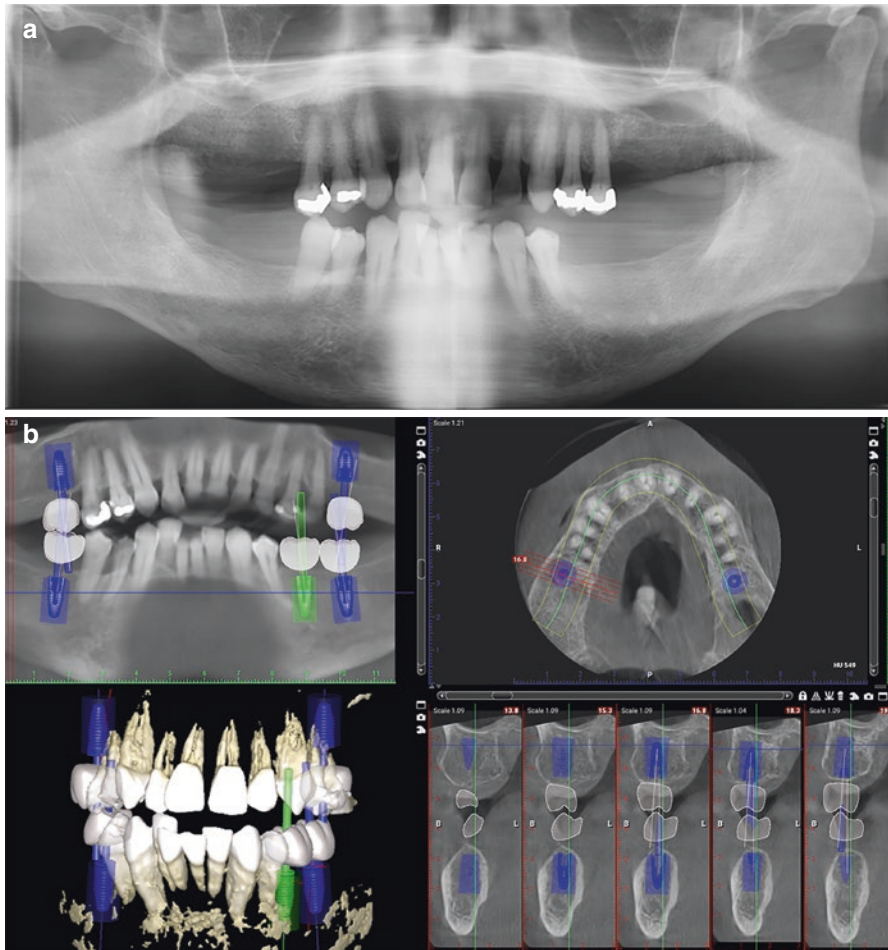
(a, b) Digital treatment planning, (a) screening panoramic radiograph, (b) CBCT with digital software planning ideal implant positions
